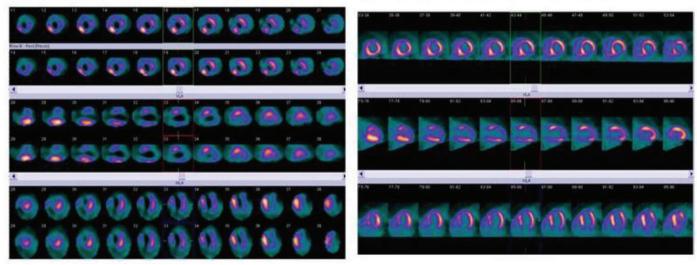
MIBI and PET/CT case 2
